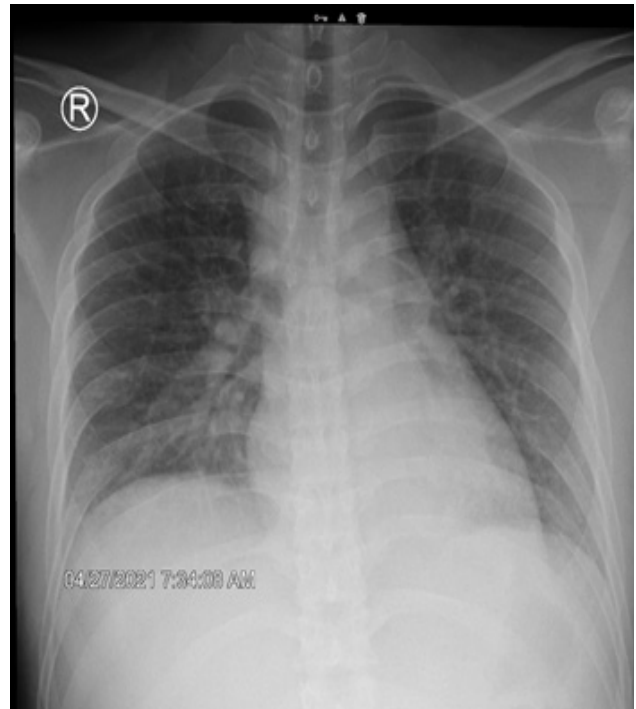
Chest X-ray showed hazy densities in the right lower lung.
